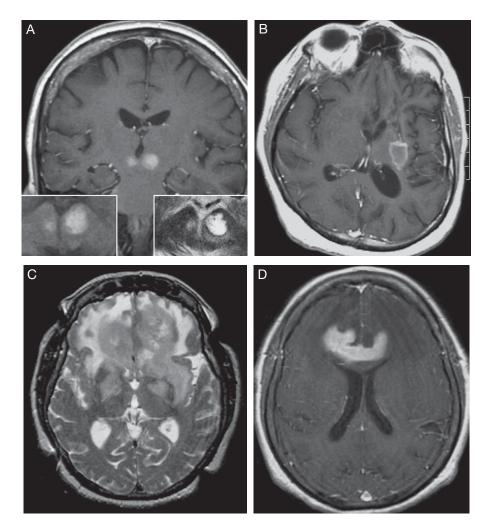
MRI of Primary Central Nervous System Lymphoma.
